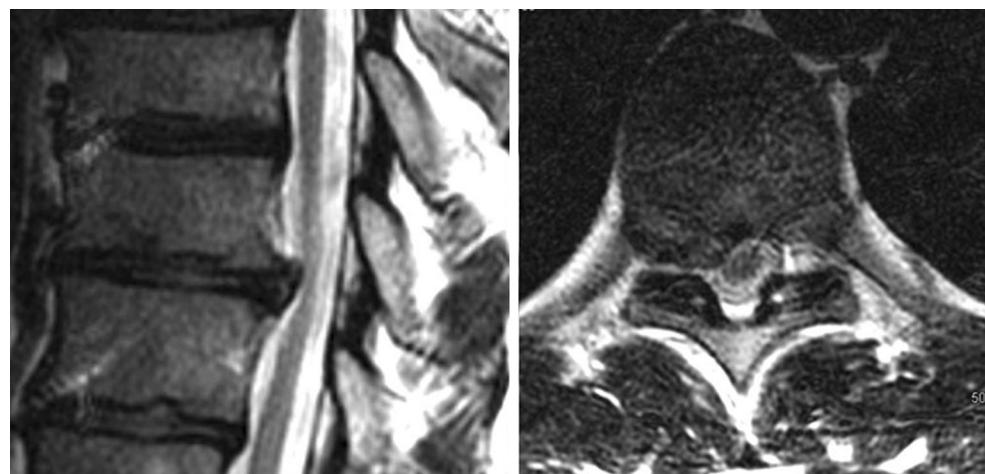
Case 1 MRI scan showing T9–T10 right paramedian disc herniation with mild spinal cord compression
